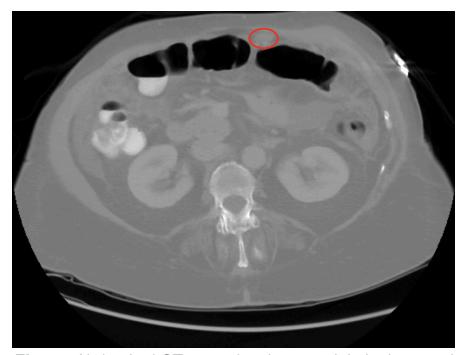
Abdominal CT scan showing a nodule in the anterior mid abdomen.
